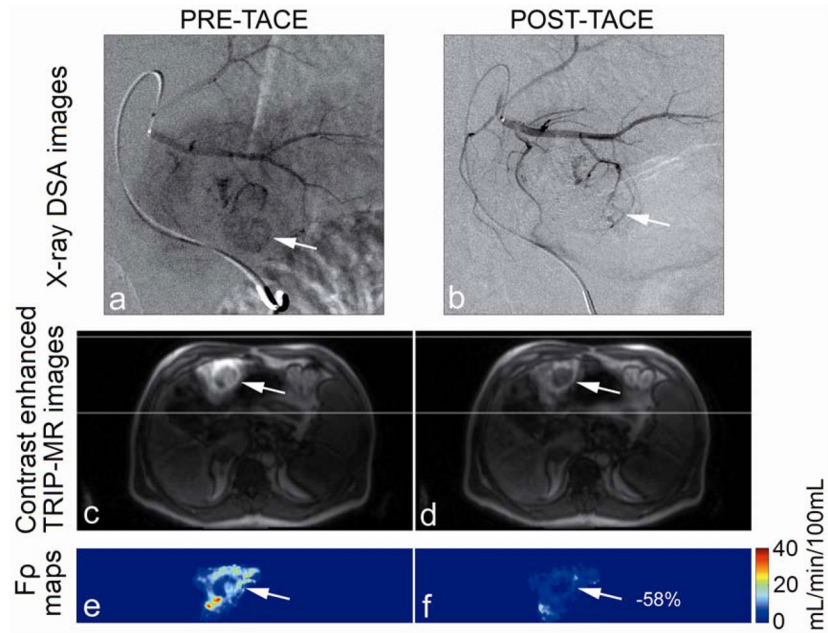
Representative x-ray DSA-MRI monitored TACE images obtained in a 51-year-old patient with segment III HCC. X-ray DSA image before TACE (a) demonstrates catheter positioning, arterial structure, normal antegrade blood flow, and tumor blush (arrow). Post-TACE x-ray DSA image (b) demonstrates reduced antegrade blood flow and no tumor blush. Axial pre-TACE 4D TRIP-MR image after intraarterial contrast injection at peak enhancement (c) shows segmental liver enhancement and tumor position (arrows), and post-TACE peak enhanced 4D TRIP-MR image (d) shows reduced tumor contrast uptake; corresponding intra-procedural pre-TACE Fp map (e) indicates baseline blood flow and post-TACE Fp map (f) indicates reduced blood flow, in the tumor within the targeted vascular territories. The percentage perfusion reduction is listed in the post-TACE perfusion map.
